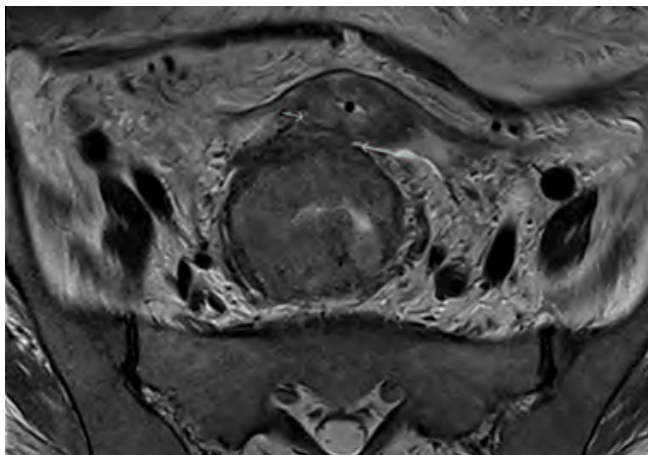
Magnetic resonance imaging scan pelvis T2 TSE Axial demonstrating fungating mass in the rectum infiltrating to posterior myometrium suggested by the same signal intensity.
